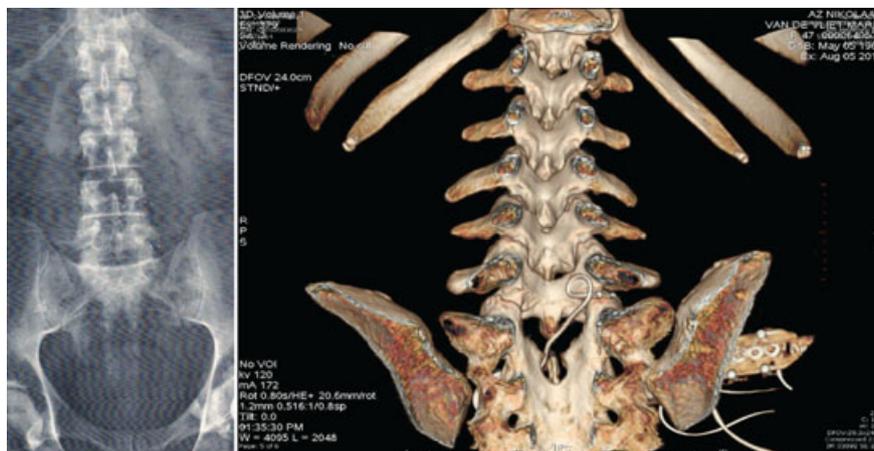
Anterior–Posterior (AP) view of leads implanted at right L4 and L5 dorsal root ganglia (DRGs) (left). 3-D reconstruction of a lead at L5 DRG using a computed tomography (CT) scan (right).
